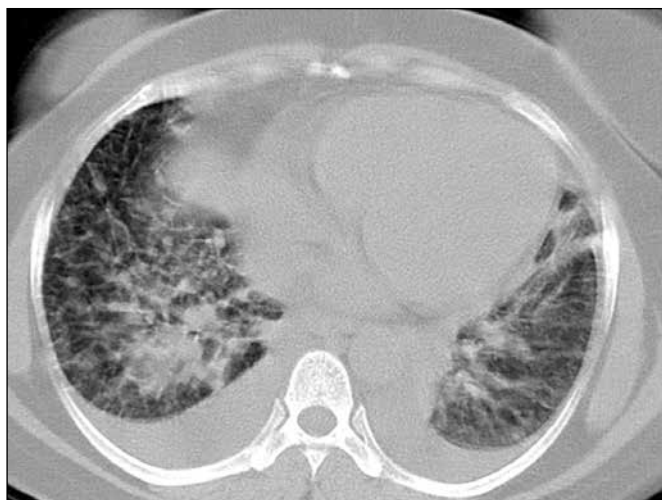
CT scan shows bilateral pleural effusion in the lower lung zones, areas of consolidation, and ground-glass opacity.
